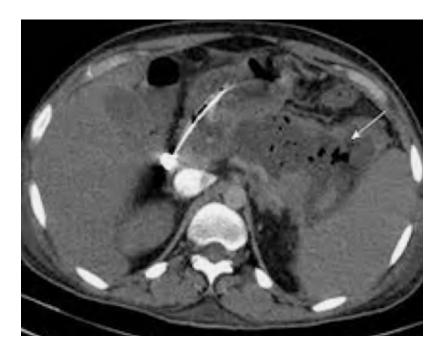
CE-CT scan showing the positioning of a percutaneous retroperitoneal drain inside a large infected necrotic collection, as the first step of a step-up surgical approach.
